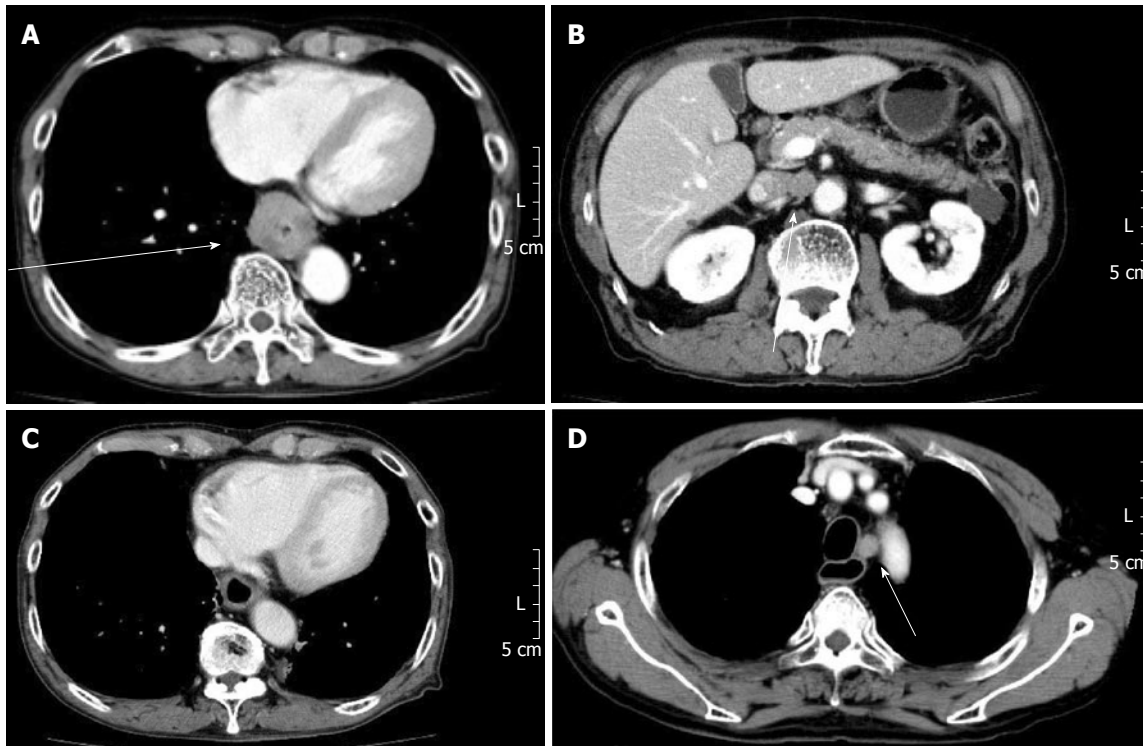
Computed tomography. A: Circumferential wall thickening and a 39 mm × 35 mm tumor on the lower thoracic esophagus; B: Swelling of the abdominal para-aortic lymph node; C: A remarkable shrinking of the mass in the lower esophagus; D: Swelling of the left para-tracheal lymph node.
